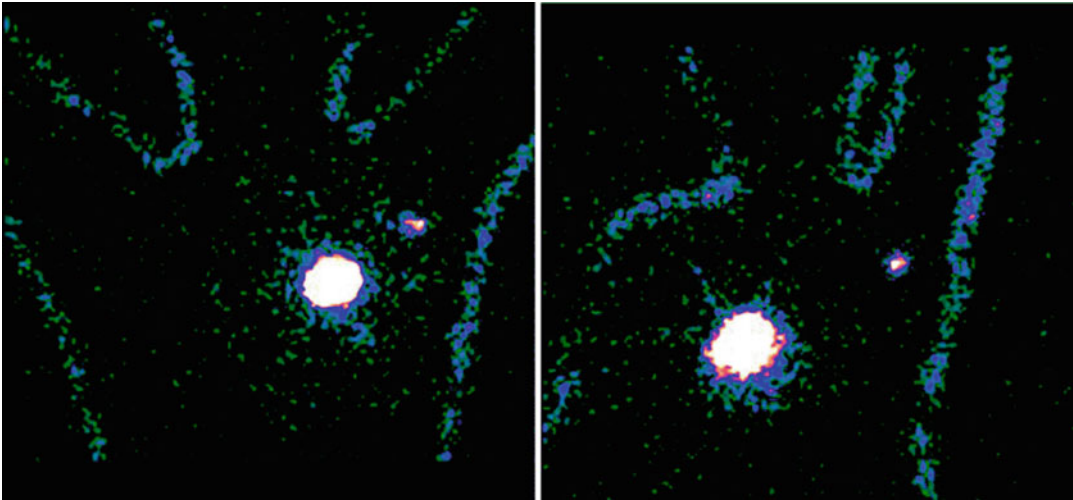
Body contour delineation obtained by moving a ^{57}Co point source along the body of the patient during acquisition of the planar scintigraphic images. In this patient with cancer of the left breast, $^{99\text{m}}\text{Tc}$ -nanocolloidal albumin was injected at four spots periareolarly. Images
